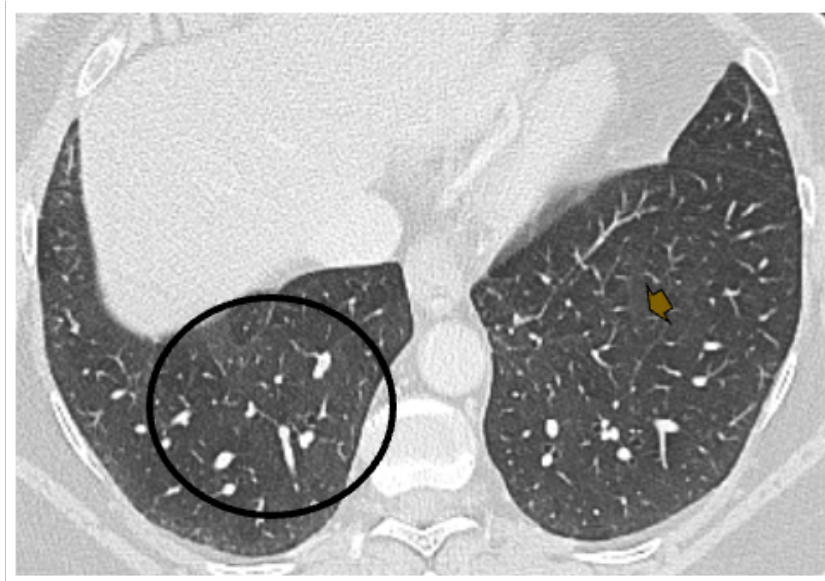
Axial CT image showing ground glass opacities (circle), associated with minimal reticular opacities (arrow) both with a prevalent central distribution, compatible with non-subpleural ILA.
